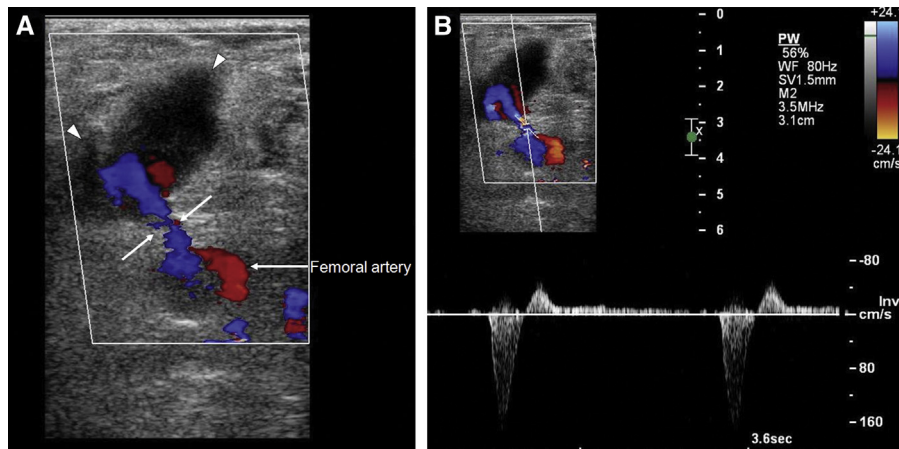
(A) Femoral artery pseudoaneurysm; transverse sonogram, showing a pseudoaneurysm (arrowheads) arising from femoral artery; the neck of the pseudoaneurysm (thin white arrows) and the sac demonstrated typical to-and-fro blood flow. Femoral artery is indicated by the (thick white arrow). (B) Femoral artery pseudoaneurysm; spectral colour-Doppler imaging, showing typical to-and-fro blood flow pattern via the neck. This figure is available in colour online at <http://carjonline.org/>.
